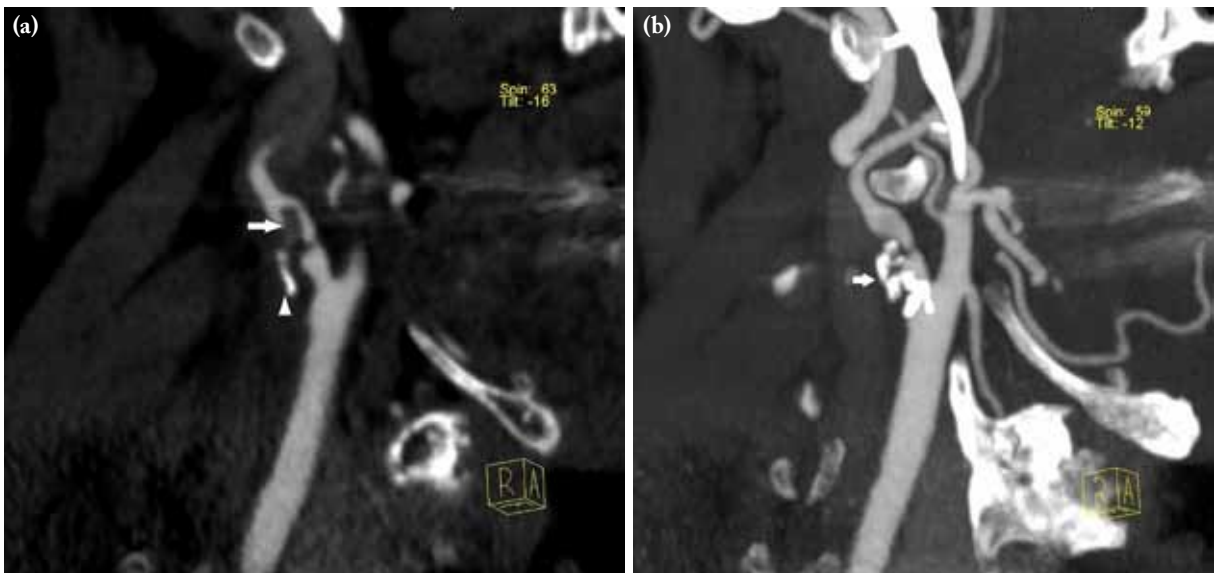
(a) Computed tomography angiography showing a right severe carotid bulb stenosis with deep plaque ulceration (arrow, pedunculated thrombus; arrowhead, bulb plaque ulcer). (b) A markedly right carotid artery stenosis (approximately 90%, arrow).
